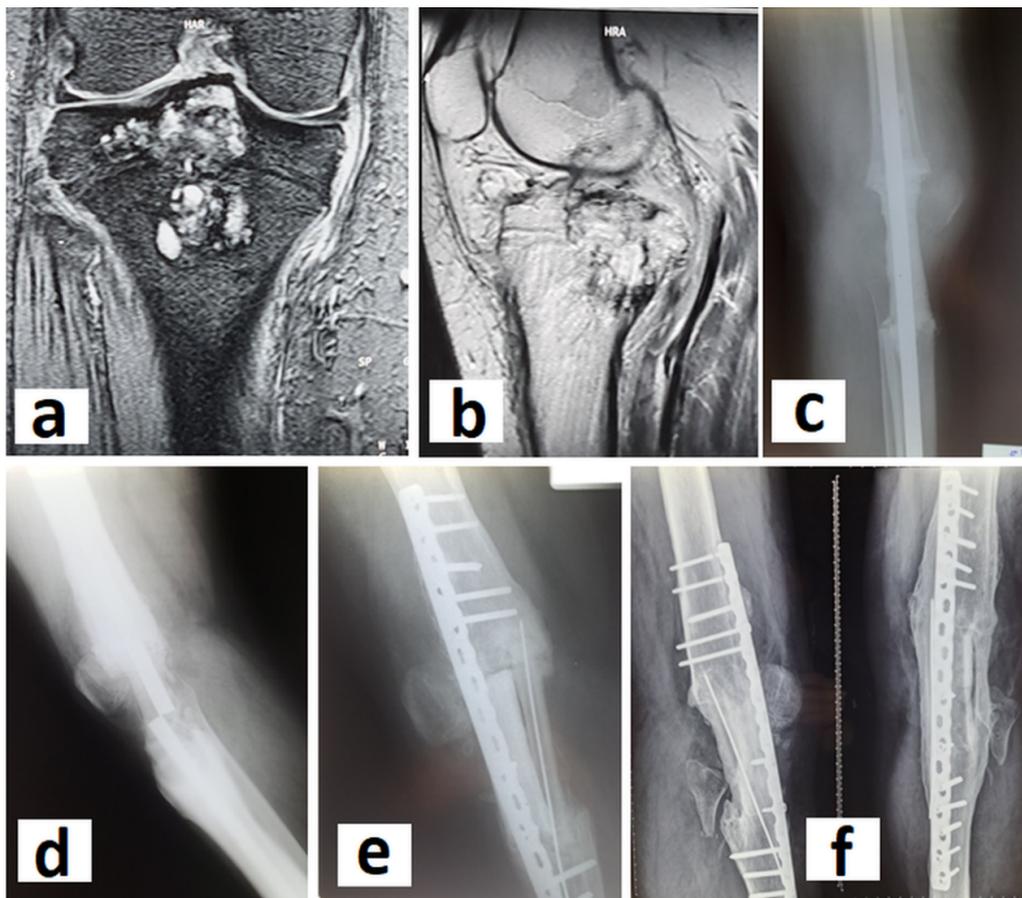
MRI scans of a 16 years old male with chondroblastoma in the right proximal tibia (5a, 5b). Resection and arthrodesis of the knee with a long intramedullary nail was performed (5c). The intramedullary nail broke at post-operative 18 months (5d). Knee arthrodesis was performed using a nonvascularized fibular graft (5e, 5f)..
